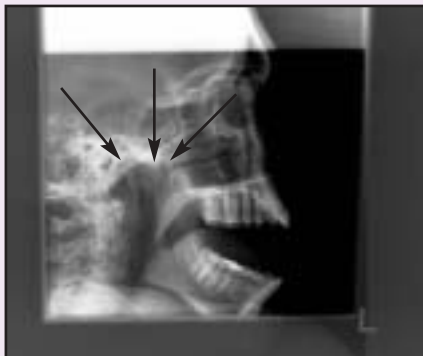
X-ray demonstrating the dislocated mandibular condyle sitting anterior to the articular eminence. Arrows, from left to right: articular fossa; articular eminence; mandibular condyle lying anterior to the articular eminence.
